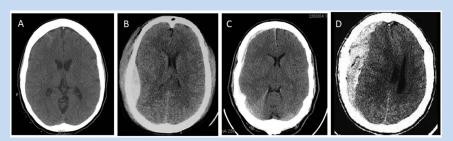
Examples of intracranial hemorrhage on head computed tomography. (A) Right frontal traumatic subarachnoid hemorrhage. (B) Right epidural hematoma. (C, D) Two images of right subdural hematomas demonstrating varying thickness of clot and degree of midline shift.
